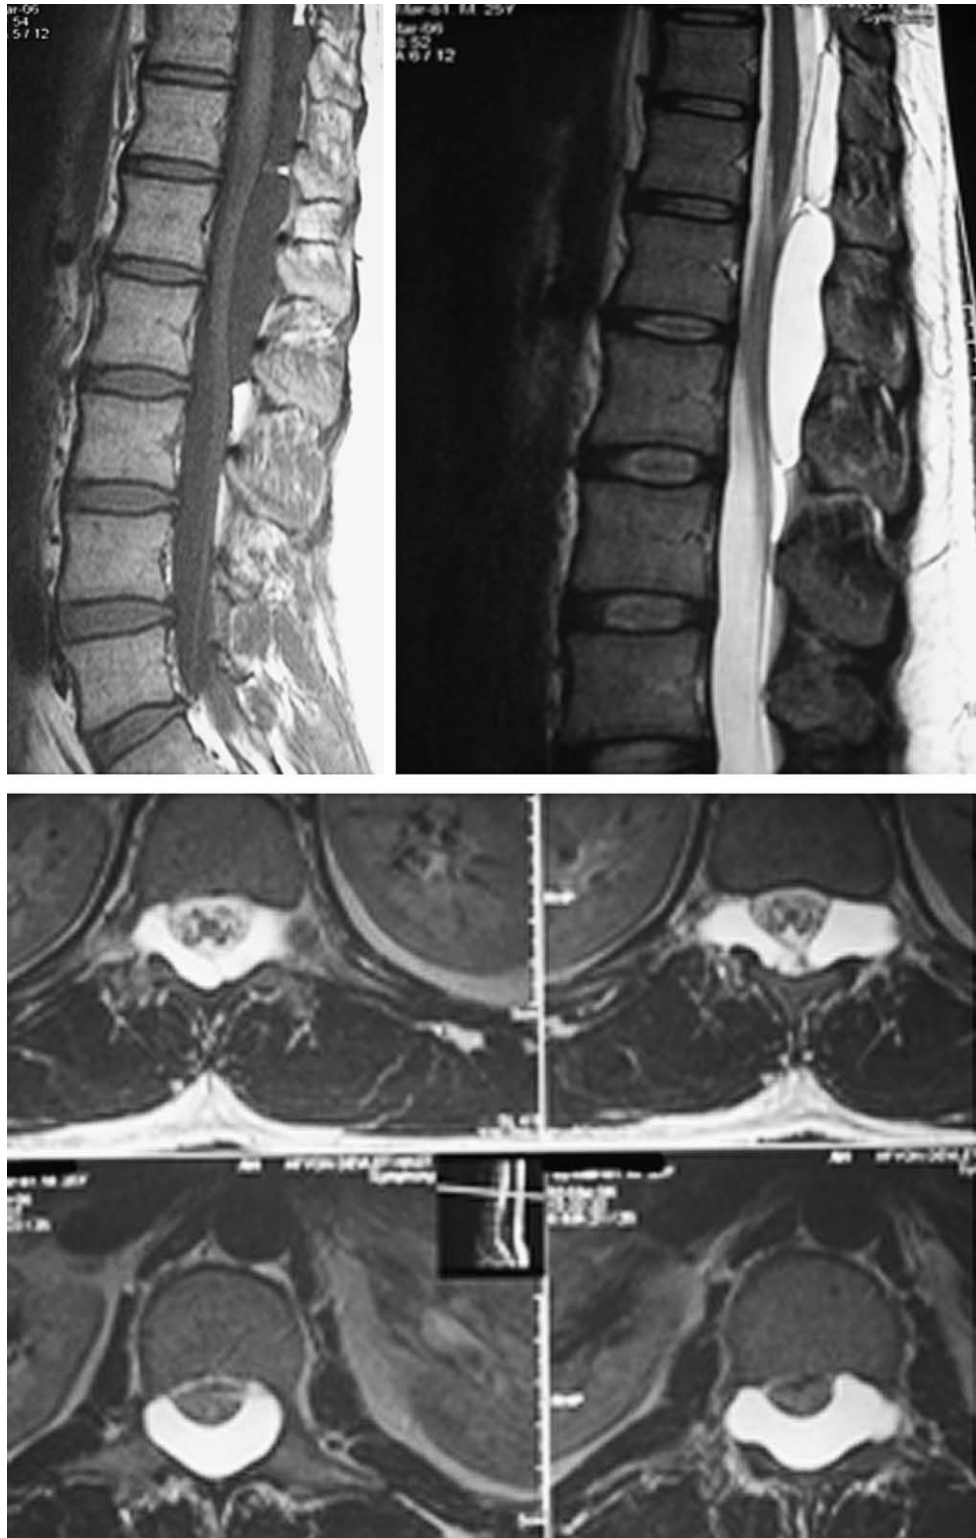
Preoperative (Top Left) sagittal T1-weighted, (Top Right) sagittal, and (Bottom) axial T2-weighted magnetic resonance imaging of the patient.
